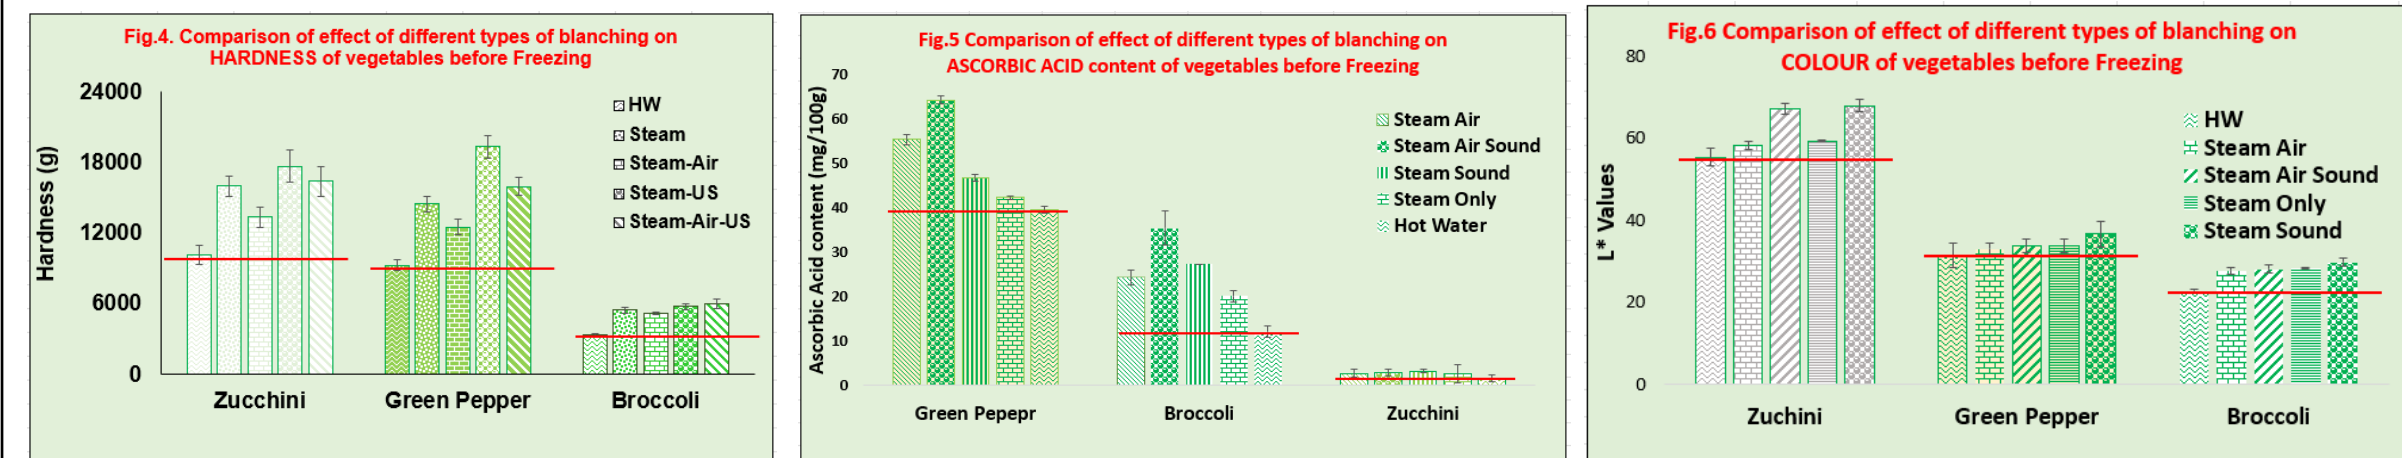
shows the effect of different blanching techniques on the quality parameters of different vegetables. The texture (hardness), color (L* values representing brightness) and ascorbic acid content retention of the vegetables were maximum when vegetables were subjected to combined steam and ultrasound blanching both in presence or absence of air compared to hot water blanching. The red line represents that hot water blanching had least retention of quality in all the vegetables
